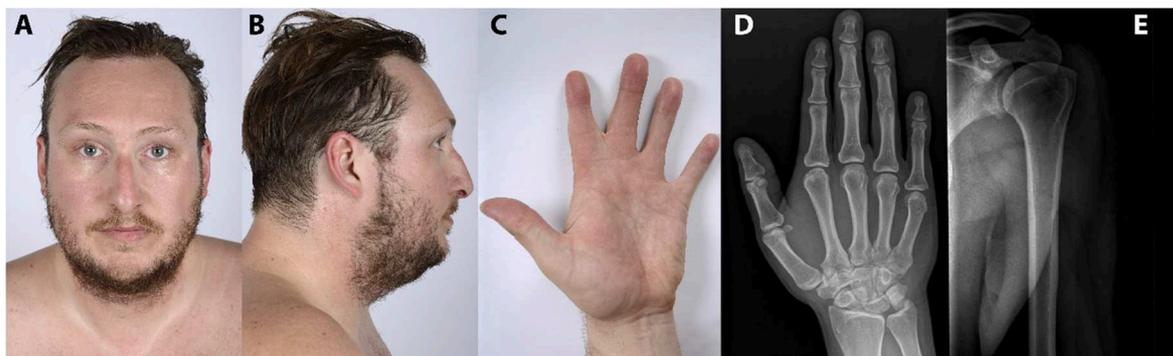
Clinical findings in patient 1. Facial features (A,B), familial hand malformation with lack of flexion crease at the 4th and 5th PIP joints (C), clear radiographical picture of symphalangism in the hand (D) and radiographic picture of the shoulder (E).
